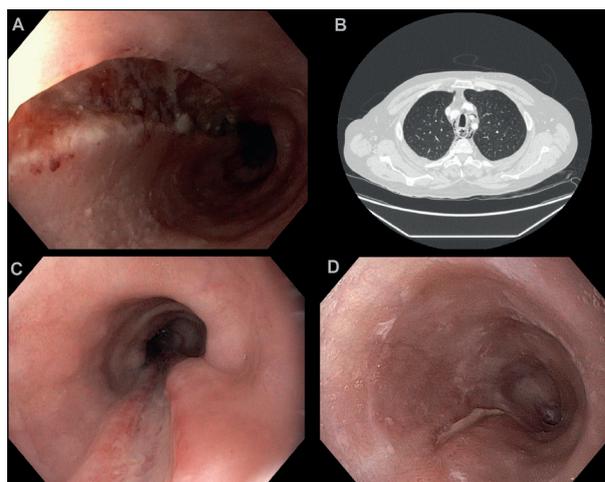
A. Gastroscopy on admission demonstrated an esophageal laceration over 10 cm. B. CT scan on admission showed mediastinal emphysema surrounding the esophagus. C. Gastroscopy after five days demonstrated the partially healed laceration. D. Gastroscopy after 6 weeks showed almost complete healing of the laceration.
